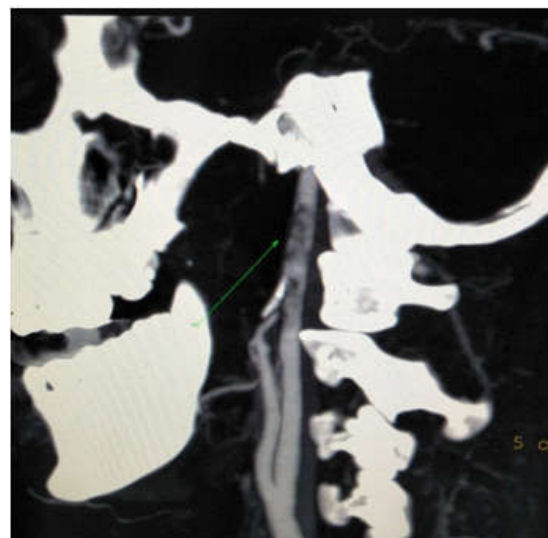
CT Angio Left side
